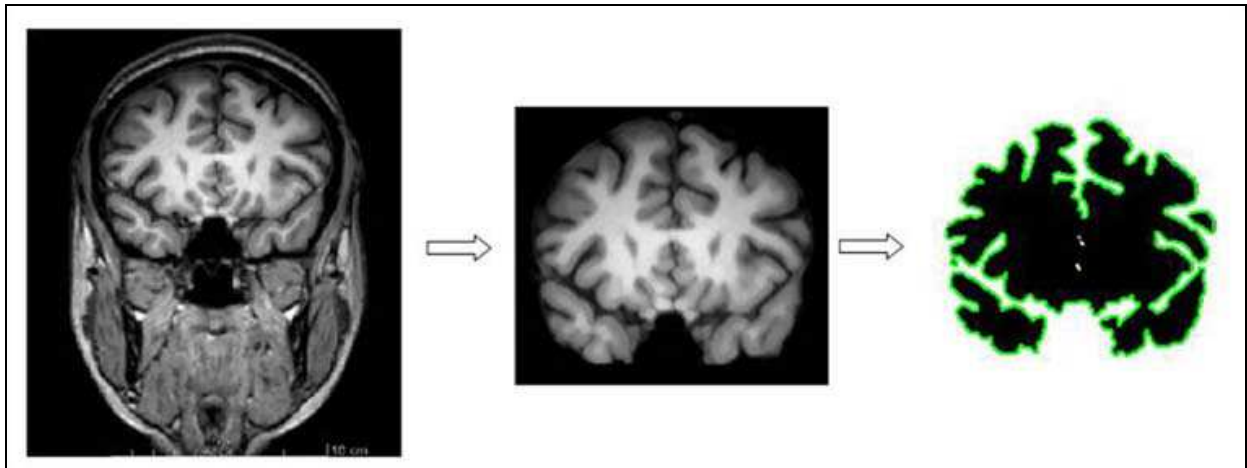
Segmentation called the Fuzzy C. Left: Original T1-weighted image. Center: Masking and removal of artifacts the outer contour of the brain. Right: Contour of segmented image is outlined
